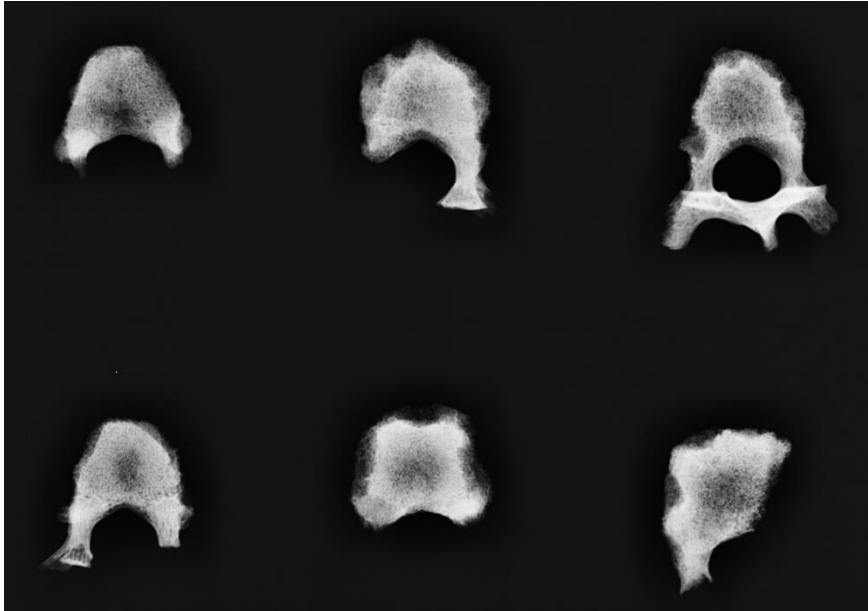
Possible brucellosis I. Radiograph of thoracic vertebrae, inferior aspect; displaying resorptive foci on anterior and lateral vertebral margins. From Bath Gate, Cirencester, skeleton 709. (with permission from Corinium Museum)
